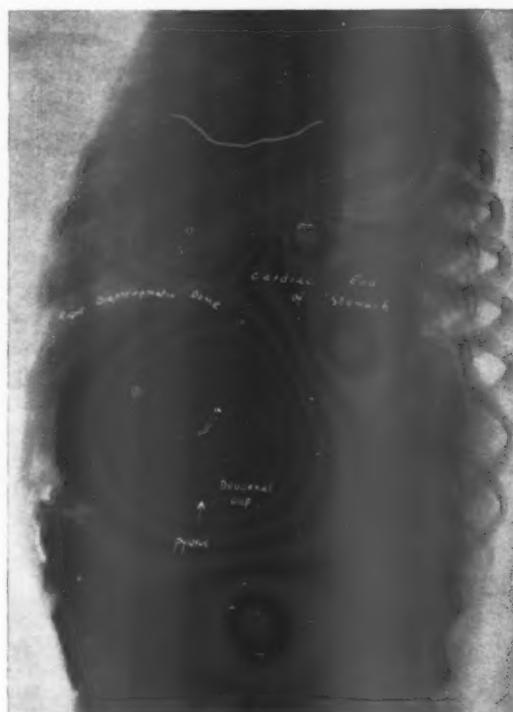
Radiograph. Case VI, showing short oesophagus and thoracic stomach.
